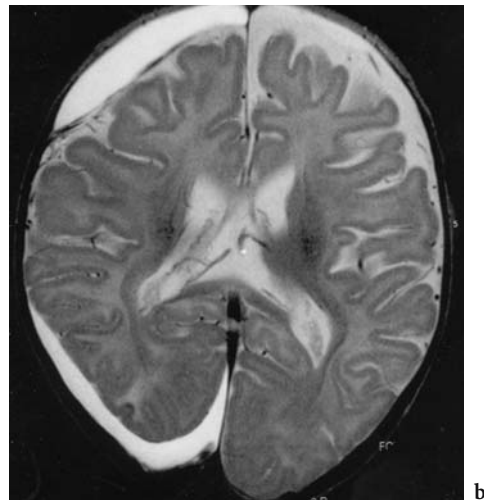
a Axial CT, b axial MRI of a 4-month-old baby admitted following seizures. Bilateral retinal hemorrhages suggested nonaccidental injury. a Brain swelling, minimal blood accumulation in interhemispheric fissure. b Three weeks later: marked atrophy and secondary subdural effusions
